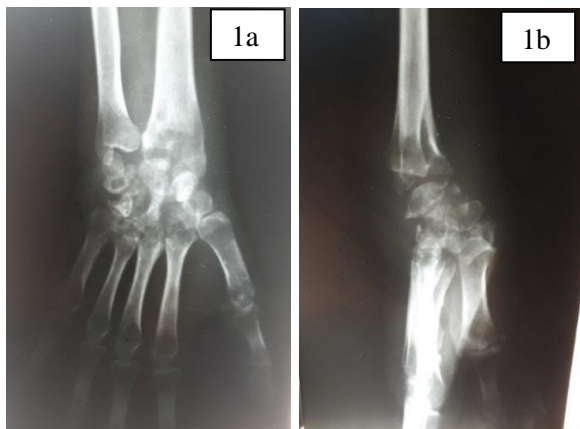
X-ray showing active tubercular arthritis of wrist
